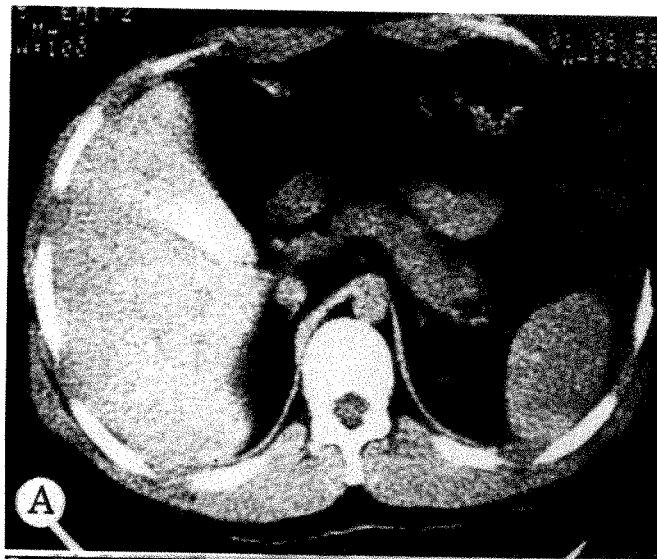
CT scans of 19-year-old man with history suggestive of pancreatitis. *A*, Highest tomographic cut includes tail and superior portion of body of pancreas. *B*, Middle cut includes body and superior portion of head of pancreas. *C*, Lowest cut is through head and uncinate process of pancreas. Second portion of duodenum located just lateral to head of pancreas and anterior to inferior vena cava.
